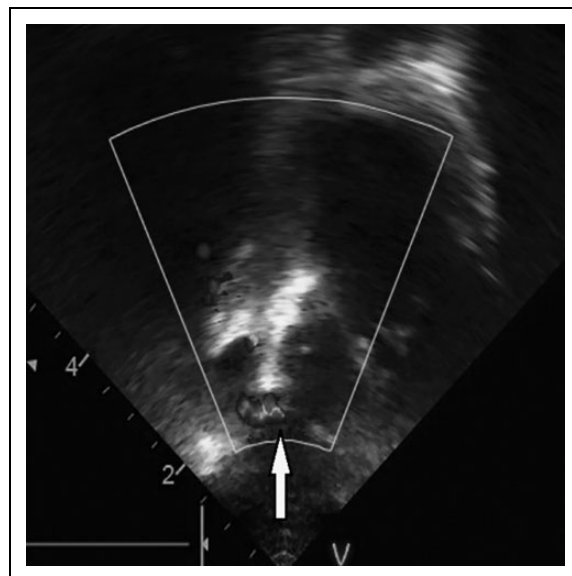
Postoperative echocardiography (modified apical four-chamber view): Device in situ, on color Doppler, small more apical ventricular septal defect visible (arrow).
